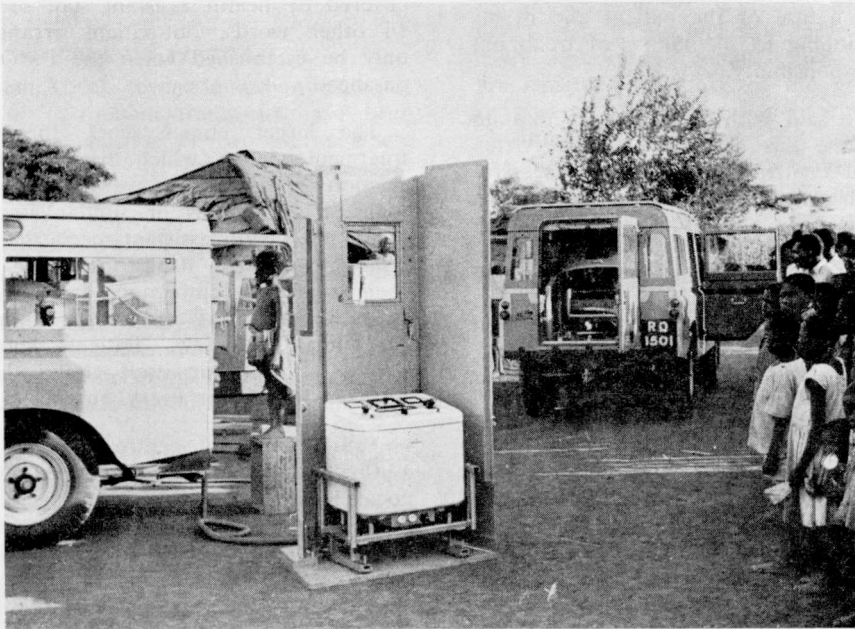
Government Mobile Radiography Unit No. 2. Siemens machine with generator, mounted on two Land Rovers. (Photo by courtesy of Que Que Rotary Club, from their project "Prevention and Cure of Tuberculosis.")
